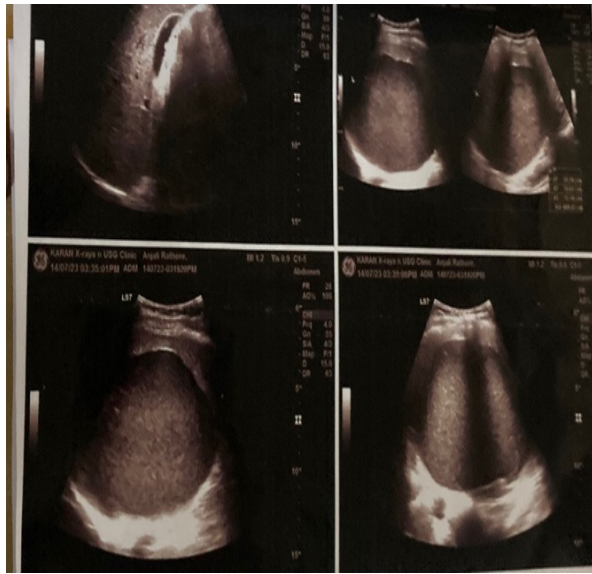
Ultrasonography of the splenic cyst
